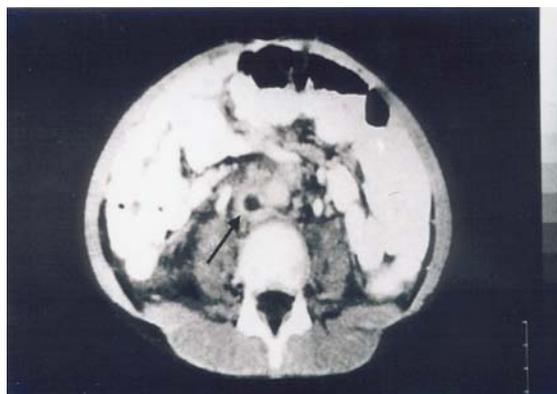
Contrast enhanced computerized tomography (CT) scan of abdomen obtained at renal vein level shows thrombosis within vena cava inferior distal to the junction of right vein to vena cava inferior giving a hypodense appearance.
